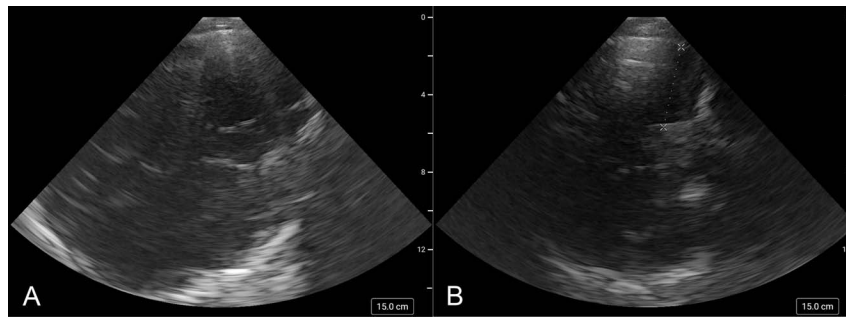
TCUS images of hypoechoic brain lesion. (A) Without calipers. (B) With calipers. TCUS, transcranial ultrasound.
